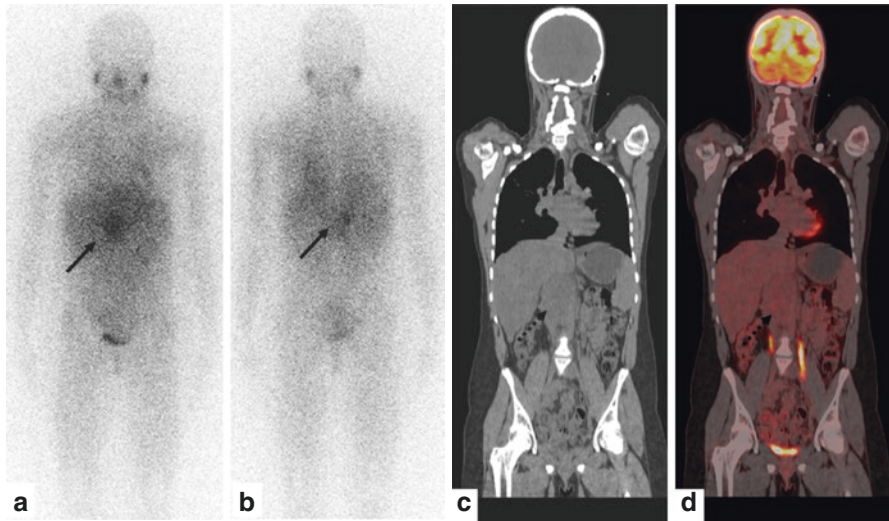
A 16-year-old female affected by stage 3 poorly differentiated abdominal NB. Residual and unresectable abdominal mass remained stable over time after treatment (chemotherapy and ^{131}I -MIBG therapy). ^{123}I -MIBG scintigraphy (planar anterior and posterior images a, b) showed inhomogeneous uptake correspondent to the big abdominal mass (arrows). The absence of ^{18}F -FDG uptake shown by coronal PET/CT images (dotted arrows) confirmed the suspected progressive maturation of this neuroblastic tumor (c, d)
